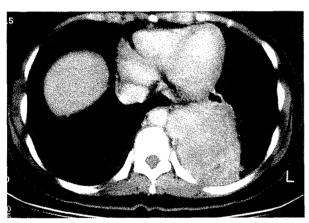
Chest CT scan at admission showing a large, ill-defined, heterogeneous, circumscribed soft tissue mass (approximately $10.5 \times 9.0 \times 7.0 \text{ cm}$) on the left lower lobe.
